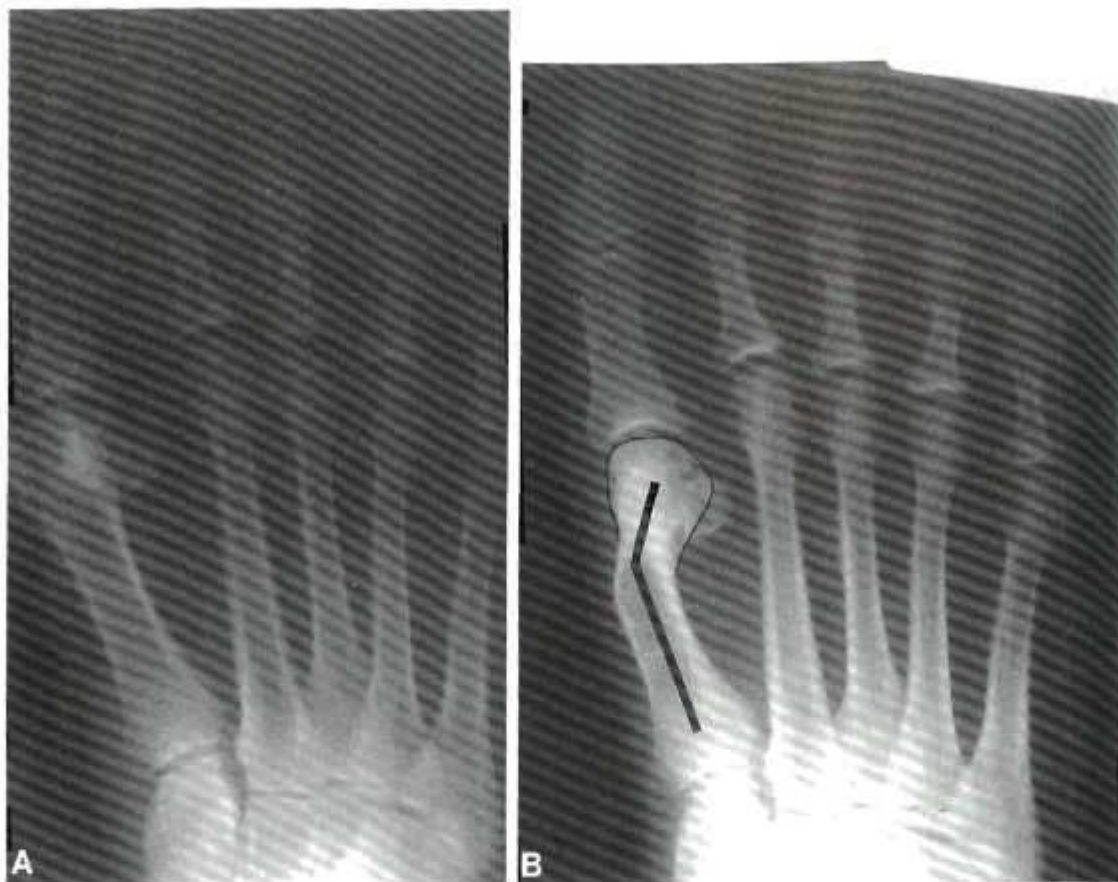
A, Preoperative anteroposterior radiograph of Chevron osteotomy. B, Postoperative anteroposterior radiograph demonstrating valgus malunion of Chevron osteotomy. This patient also had a lateral capsule and adductor release.
